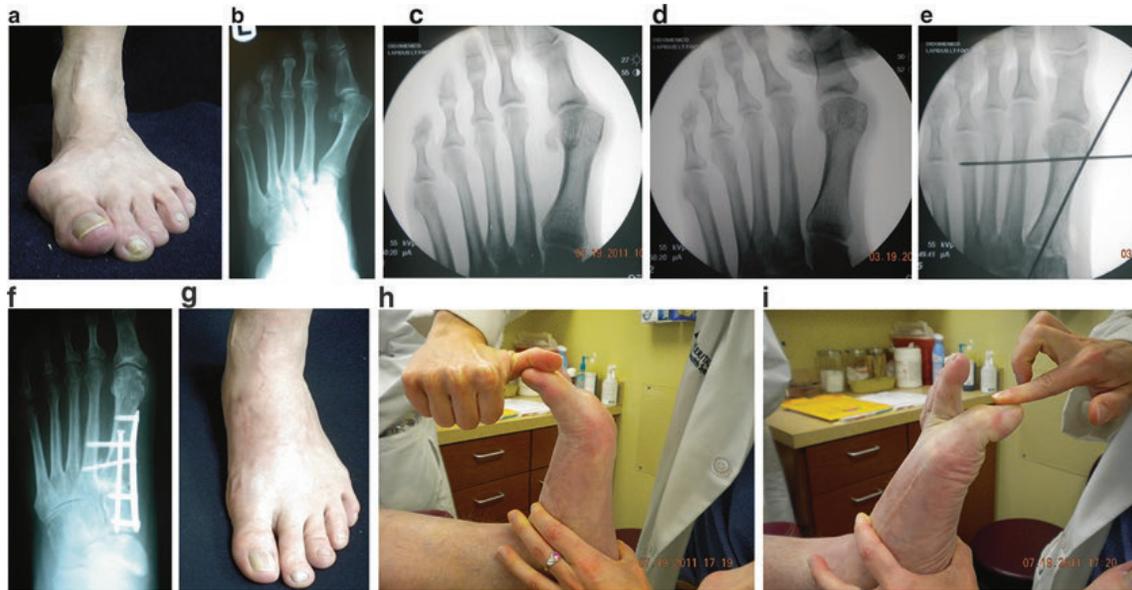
(a) A clinical photo of a patient who presents with a painful HAV deformity. Note the valgus rotation of the great toe. (b) An AP radiograph of the same patient demonstrating a large IM angle, diastasis of the base of the first and second metatarsal, as well as the cuneiforms. There is a valgus rotation of the great toe, first metatarsal, and subsequently a valgus rotation of the sesamoid complex. (c) An intraoperative radiograph of the same patient demonstrating the sesamoid completely in the first interspace and the articular surface of the fibular sesamoid is 90° to the lateral aspect of the first metatarsal. (d) An intraoperative radiograph of the same patient demonstrating the great toe in the varus direction to a neutral position rotates the entire first metatarsal, great toe, and sesamoid complex as an entire unit. Note the sesamoid are placed into an anatomic position when a frontal plane is
